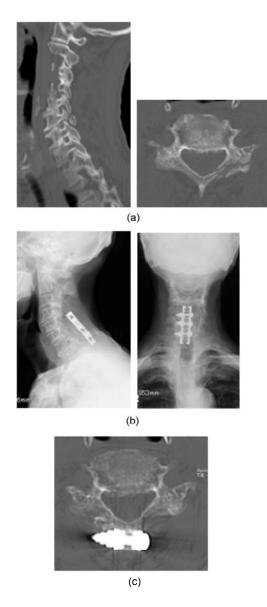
CT scans and plain X-ray images of Case 1 (a) Cervical CT scans demonstrating displacement of left C6 facet fracture with dislocation, and C6 laminar fracture (left: sagittal image; right: axial image); (b) Plain X-ray images showing posterior spinous process plate fixation after surgery (left: lateral view; right: anterior-posterior view); (c) Axial cervical CT scan showing posterior bony fusion and fracture healing at the C6 vertebra
